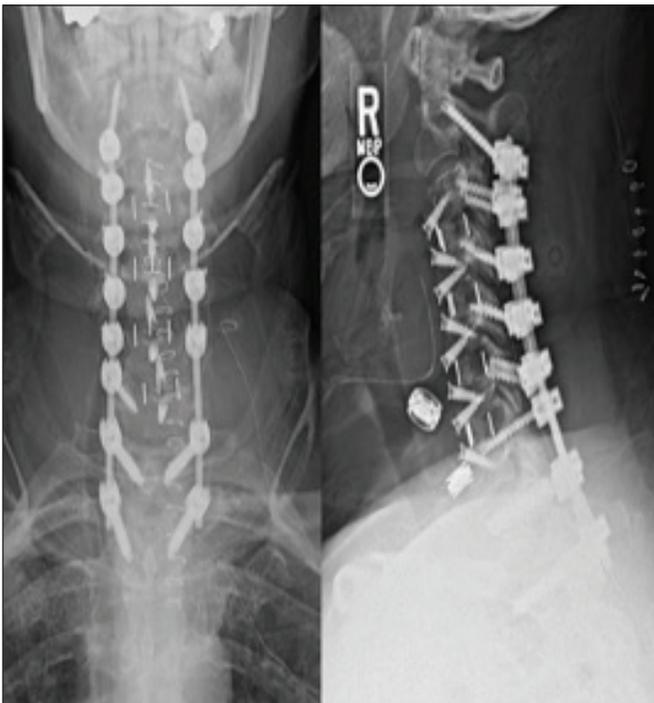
Postoperative anteroposterior and lateral radiographs obtained after single-day combined C3–7 ACDF, C2–T2 PSF, and C3–7 laminectomy. ACDF: Anterior cervical discectomy and fusion, PSF: Posterior cervical stabilization and fusion.
